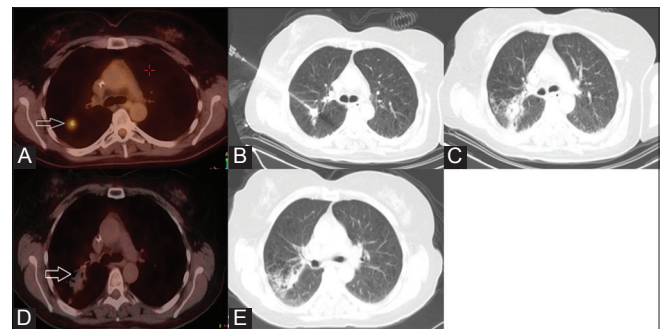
(A-E): A 56-year-old male with NSCLC. (A) Pre-RFA PET-CT scan (Siemens Healthcare, Knoxville, Tennessee, USA) shows a lung nodule measuring 1.4 × 1.4 cm in the right lower lobe, SUV 4.9 (white arrow) (B) CT-guided RFA performed using an RF ablation system (Boston Scientific, Natick, MA, USA) (C) A large area of GGO is seen around the nodule immediately after ablation (D) PET-CT performed the next day shows GGO around the nodule. However, there is resolution to background of the fluorodeoxyglucose (FDG) activity (white arrow) (E) CT follow-up at 3 months shows residual GGO, but no obvious increase in the solid aspect of the nodule
